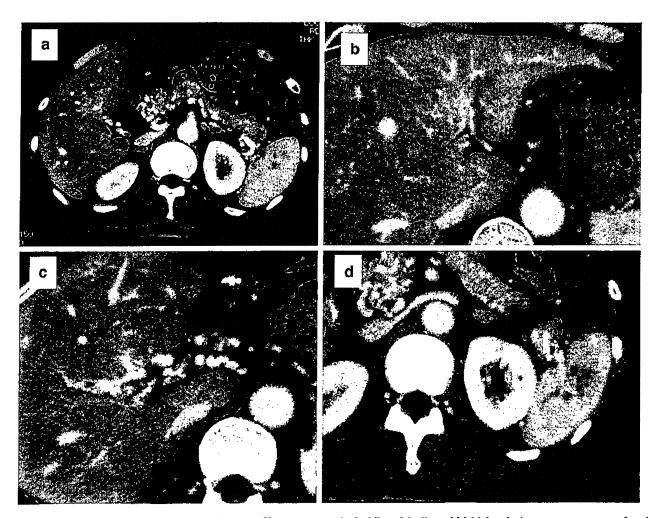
Abdominal CT findings after chemotherapy. a Huge tumor thrombosis was not identified in the portal vein. b Tumor thrombosis of the intrahepatic also disappeared. c Collaterals were partially found
